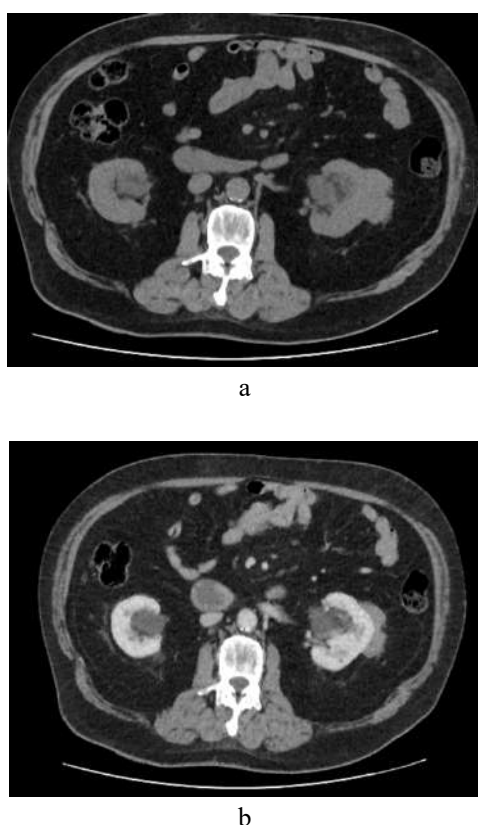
Axial-section CT scan without contrast (a) and after contrast administration in the portal phase (b).
